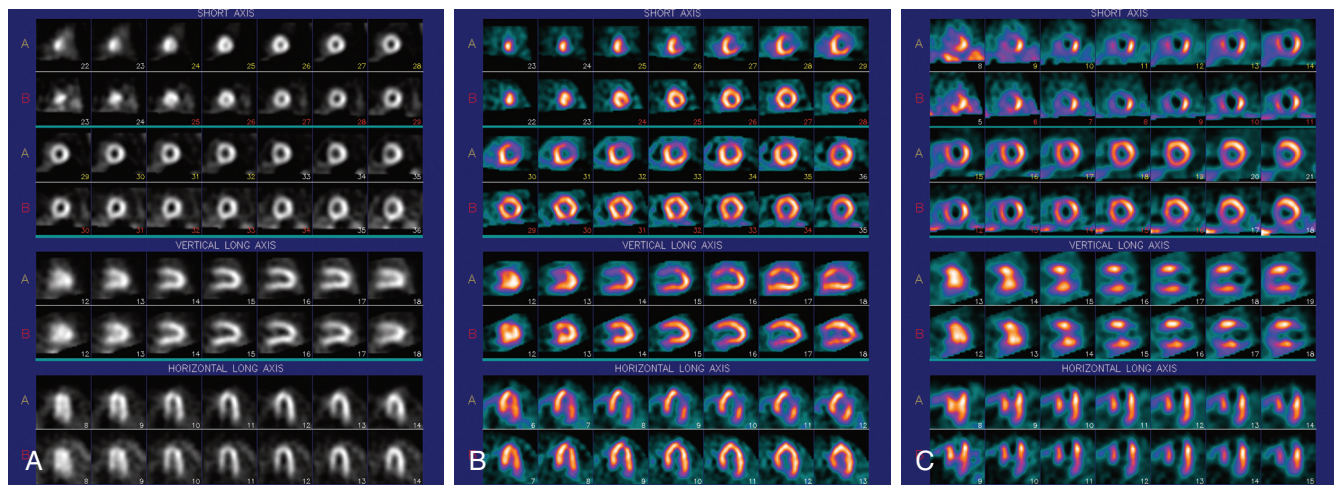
■ Visual display of single photon emission computed tomography (SPECT) myocardial perfusion images. The stress study (rows labeled A) is shown immediately above the rest study (rows labeled B) for comparison. There are three representations of the same imaging procedure, each oriented differently: short-axis slices from apex to mid-ventricle and mid-ventricle to base (*top*), vertical long-axis slices from septum to lateral wall (*middle*), and horizontal long-axis slices from inferior to anterior wall (*bottom*). A, Normal study in grayscale, with uniform uptake of radiotracer on stress and rest. B, Color-enhanced study in which the stress images demonstrate a perfusion defect in the anterolateral wall, as evidenced by less radiotracer accumulation relative to other regions of the left ventricle. As the corresponding rest images show normal perfusion throughout the myocardium, the perfusion defect is considered “reversible,” consistent with ischemia. C, These SPECT images demonstrate large perfusion defects in the anteroapical, inferoseptal, and apical regions, which are present on both the stress and rest images. Because these defects do not show any change from stress to rest, they are termed *fixed defects*, consistent with scar (i.e., prior myocardial infarction).
